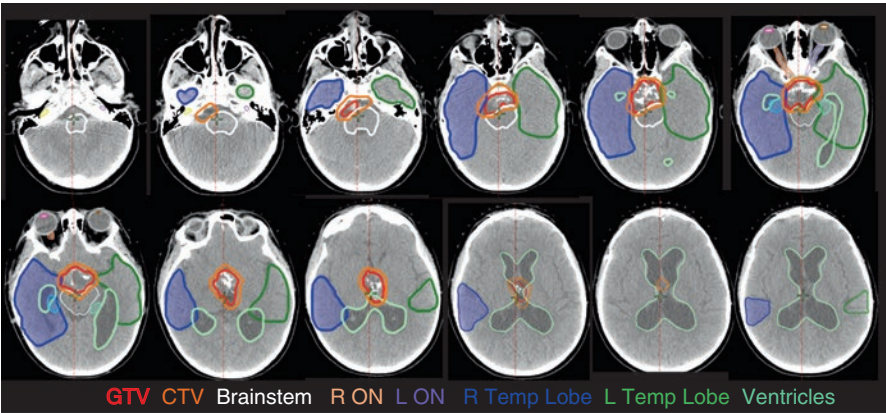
Case 3. Axial non-contrast CT scan of large heterogeneous mixed cystic solid mass. Of note, a shunt catheter has been in place for management of increased intracranial pressure
